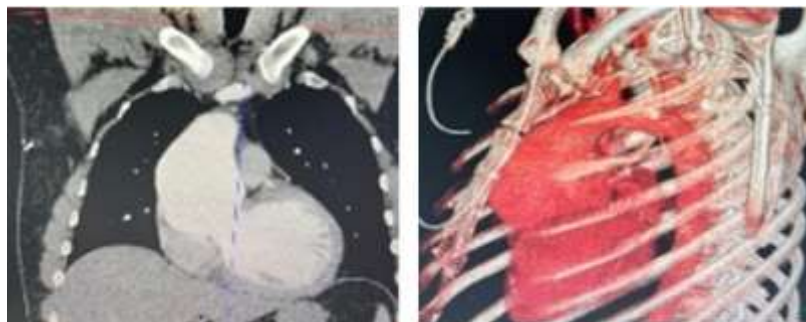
(aortic CT angiography) significant dilation of the ascending aorta without dissection and without involvement of the aortic arch
